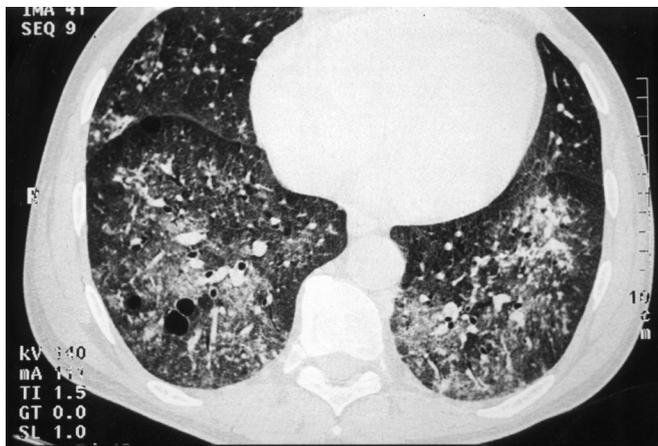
Patterns of generalization: Evolution of vasculitis after an initial granulomatous phase without prominent granulomatous inflammation in the generalized phase. The patient had an initial phase with biopsy-proven granulomatous inflammation limited to the upper respiratory tract (nasal cavity, sinus and mastoid process) lasting for 3 months. Fulminant generalization with pulmonary-renal syndrome, arthralgia, myalgia, palpable purpura, leg ulcers, night sweats, weight loss and detection of c-ANCA and PR3-ANCA were evidenced within 2 weeks. Alveolar hemorrhage and multiple pulmonary infiltrations are seen on this high resolution CT of the thorax.
